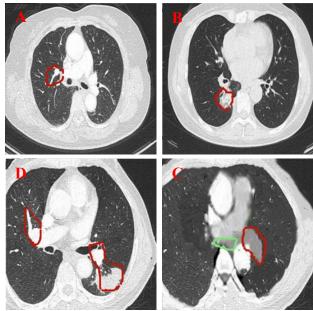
CT images of different clinical stages (A is IA, B is IB, C is IIIA, D stands for lymph node metastasis, red indicates primary tumor, and green indicates metastatic lymph nodes).
